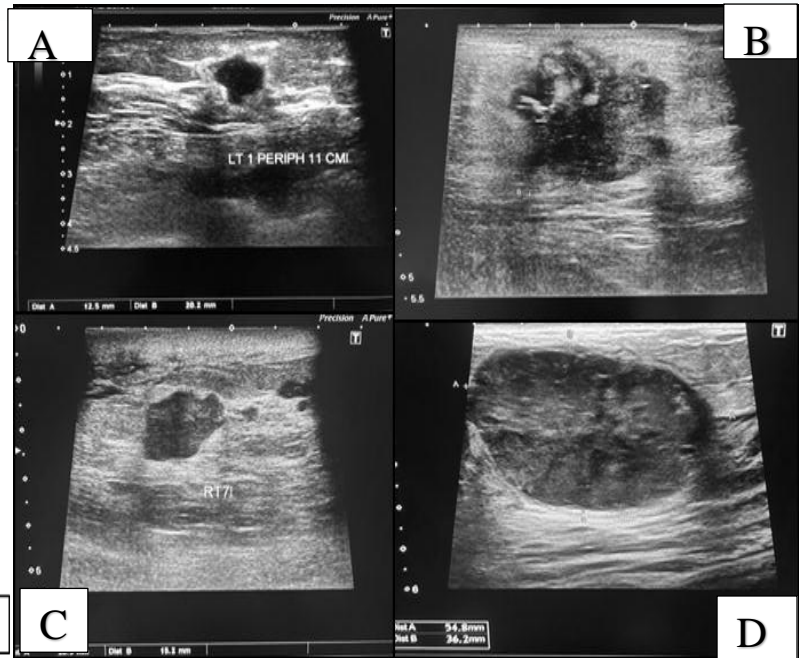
Ultrasound of 4 molecular subtypes. (A) Luminal A subtype shows spiculated strongly shadowing mass lesion with surrounding desmoplastic reaction. (B) Luminal B subtype shows spiculated mass lesion with surrounding desmoplastic reaction. (C) HER-2 enriched subtype shows irregular mass lesion with intralesional calcifications. (D) Triple negative subtype shows oval shaped mass lesion with no desmoplastic reaction.
